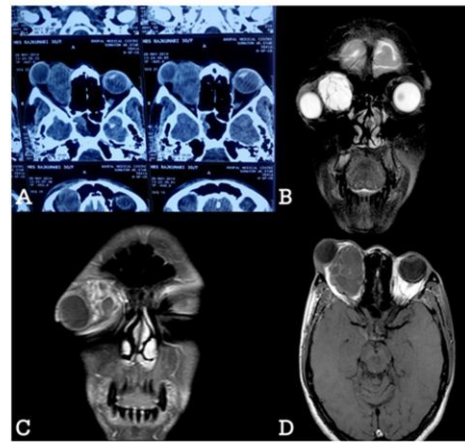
(A) CT Scan, (B) T2 W image axial, (C) T1 W image coronal with contrast, (D) T1 W image pre contrast
